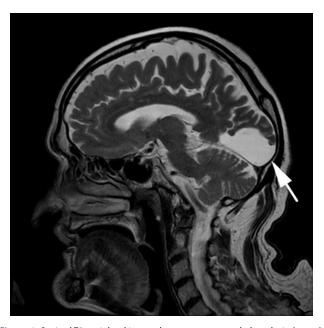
Sagittal T2-weighted image demonstrates encephalomalacia (arrow) following cerebral ischaemia comprising visual cortex in an 83-year-old man
